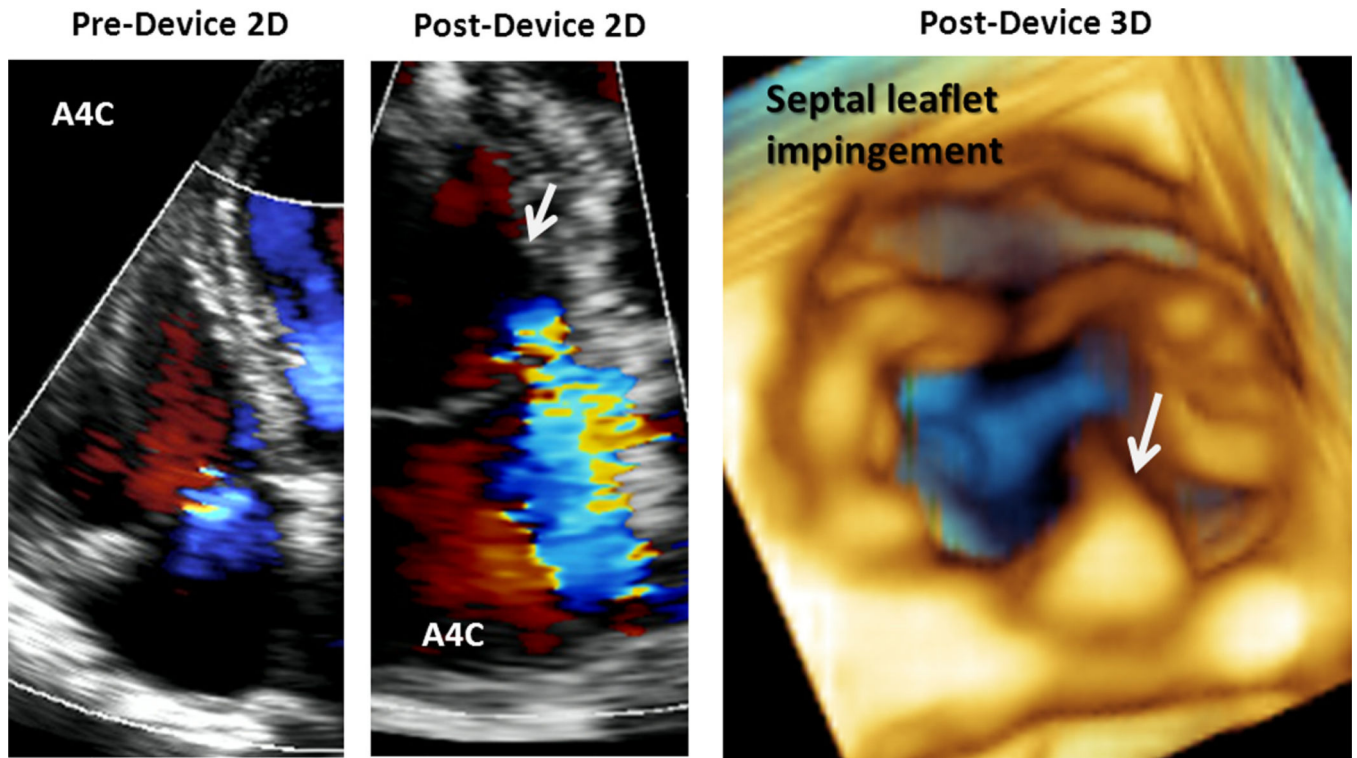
Septal leaflet impingement. Color flow recordings of the TV showing mild TR before device lead placement (*left*) and moderate TR after device lead implantation (*middle*). Three-dimensional zoom (*right*) confirms septal leaflet impingement. *White arrow* points to device lead. *A4C*, Apical four-chamber. See also Video 1.
